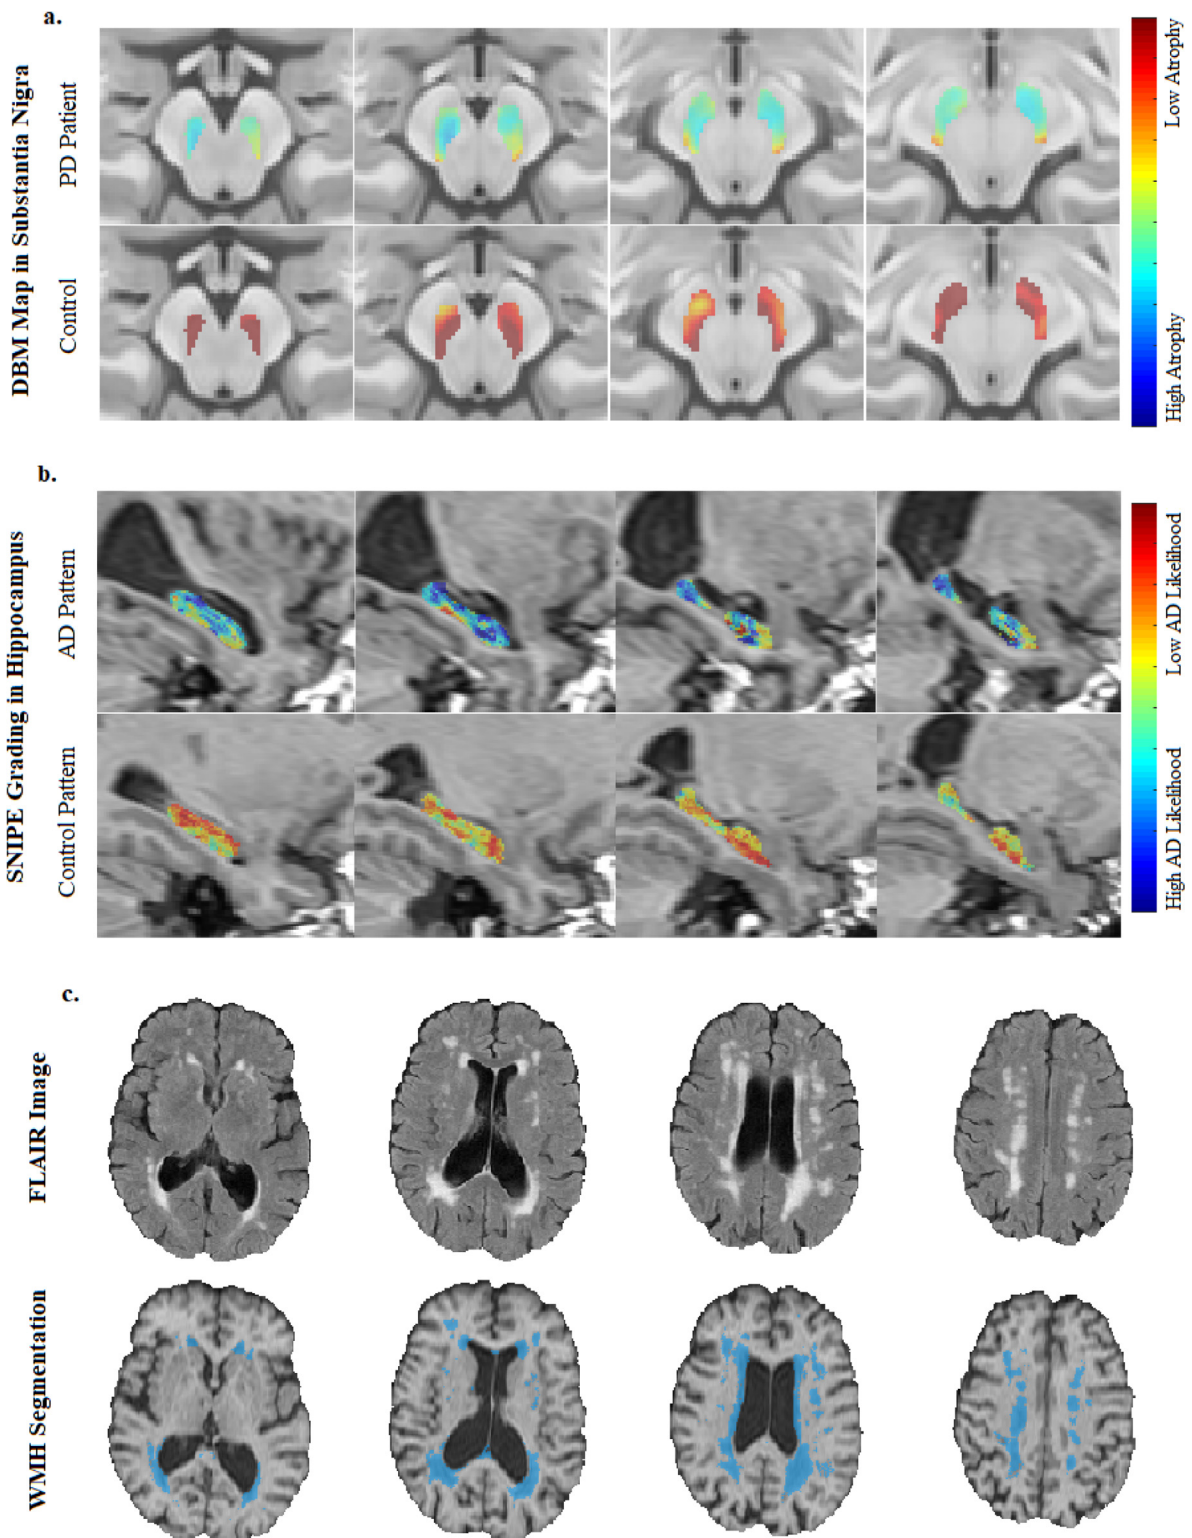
Extracted MRI Measurements: a. DBM maps in the substantia nigra mask for a PD and a control participant, b. hippocampal SNiPE grading for an AD-like and a control-like participant, and c. axial FLAIR scans and corresponding WMH segmentations. MRI = Magnetic Resonance Imaging. FLAIR = FLuid-Attenuated Inversion Recovery. WMH = White Matter Hyperintensity. DBM = Deformation Based Morphometry. PD = Parkinson’s Disease. SNiPE = Scoring by Nonlocal Image Patch Estimator. AD = Alzheimer’s Disease.
